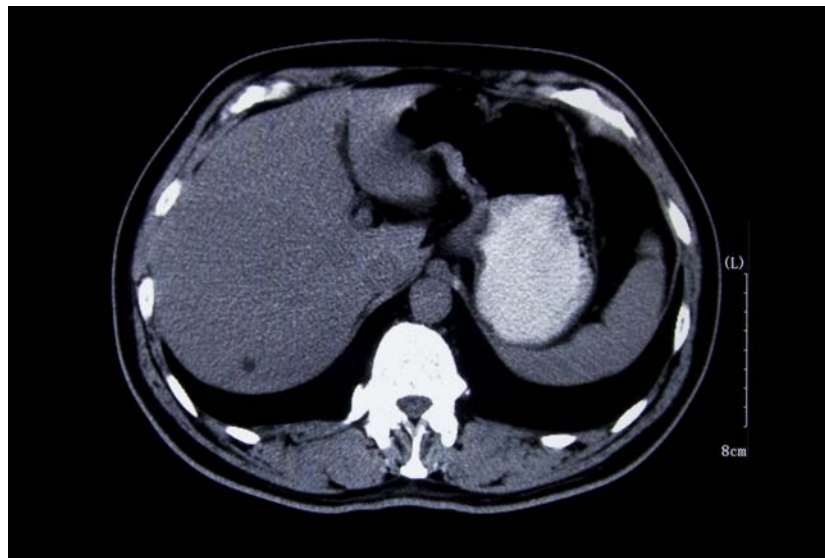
Axial CT image of the upper abdomen.
